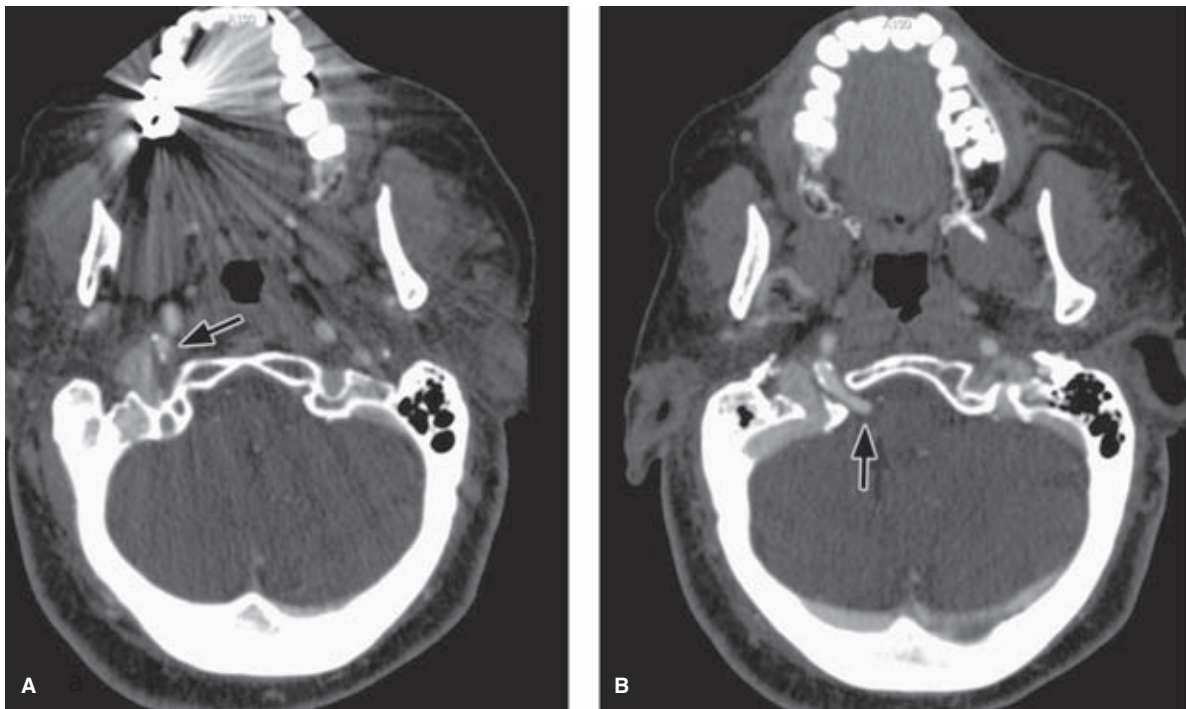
Hypoglossal artery. Two axial images from a CTA examination demonstrate an unusual vessel arising from the cervical segment of the internal carotid artery and entering the skull through the hypoglossal foramen (*arrow*).
